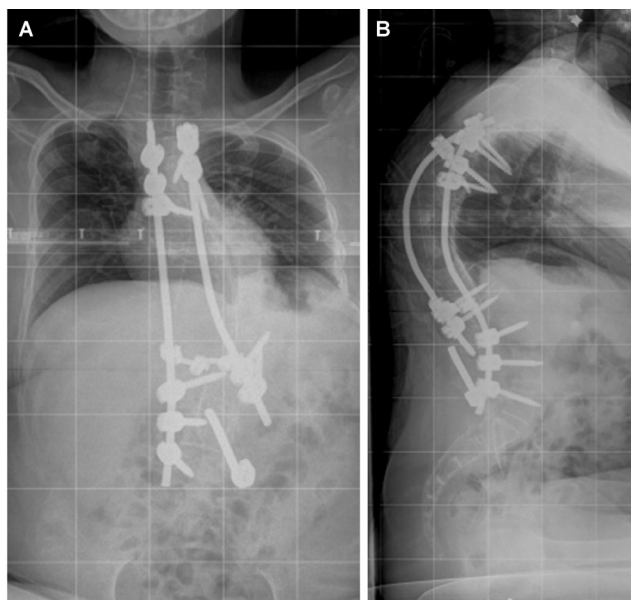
Antero-posterior (A) and lateral (B) view radiograph of a VEPTR graduate who went through VEPTR extensions, removal of VEPTR, halo traction, and definitive fusion in the form of posterior instrumented scoliosis correction. Note the improvement in space available for the lung. Distal section of VEPTR was left in situ. VEPTR, vertical expandable prosthetic titanium rib.
